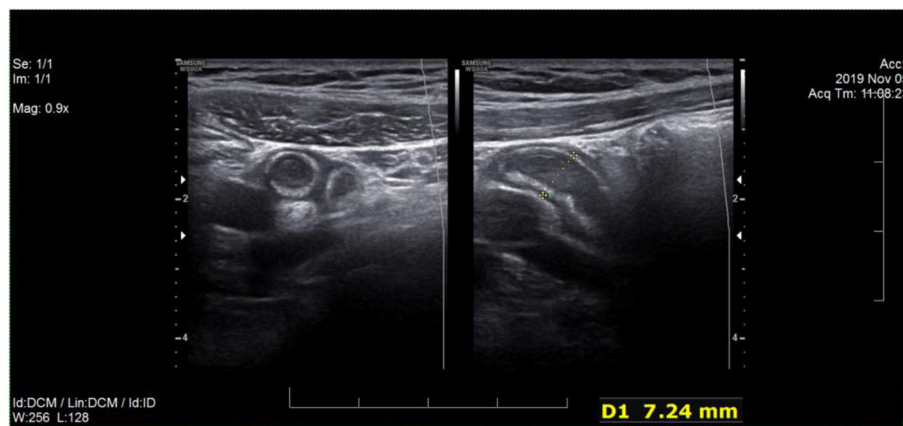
Non-compressible blind loop with A-P diameter more than 6 mm and target shape at its transverse view with adjacent hyper echogenicity of peripheral fat and luminal distention is noted which showed increased blood flow around the blind loop in color Doppler study in favor of appendicitis
